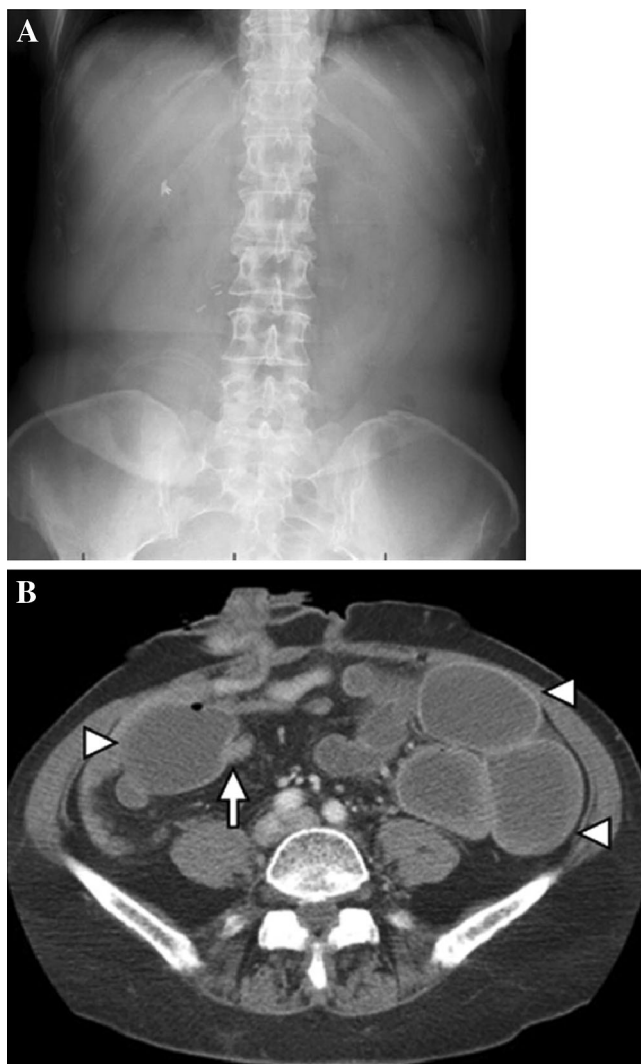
Limitations of abdominal radiography vs. CT in evaluating a patient with suspected SBO. A Supine abdominal radiograph demonstrates a gasless abdomen, thus limiting the detection of dilated fluid-filled small bowel loops. B Axial contrast-enhanced MDCT image in the same patient demonstrates dilated fluid-filled bowel loops (*arrowheads*) with an abrupt transition zone (*arrow*) into decompressed distal small bowel loops, confirming the diagnosis of SBO. The obstruction resolved following conservative management.
